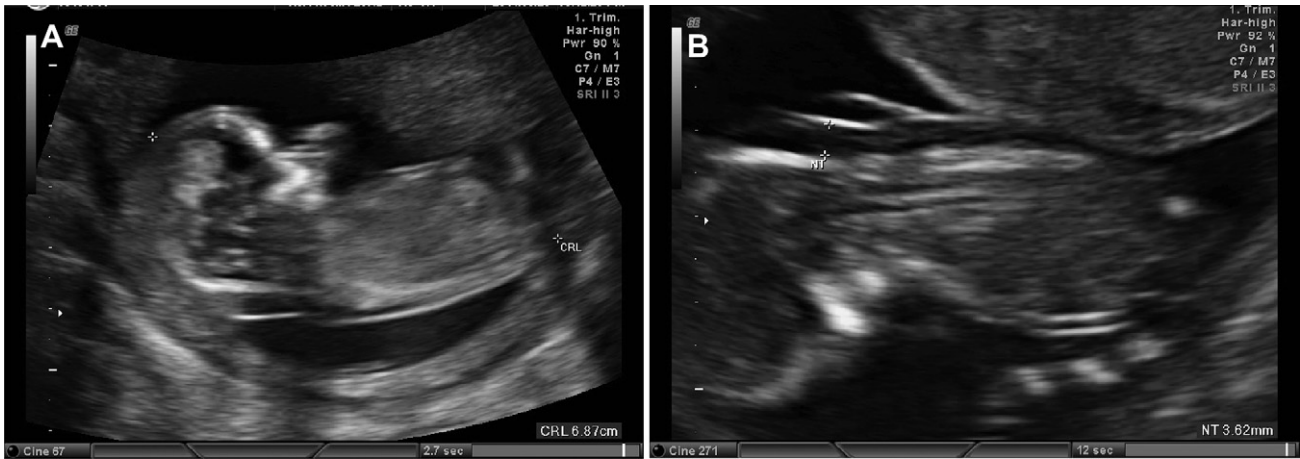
Prenatal ultrasound at 13 weeks of gestation shows an increased thickness of nuchal translucency.
